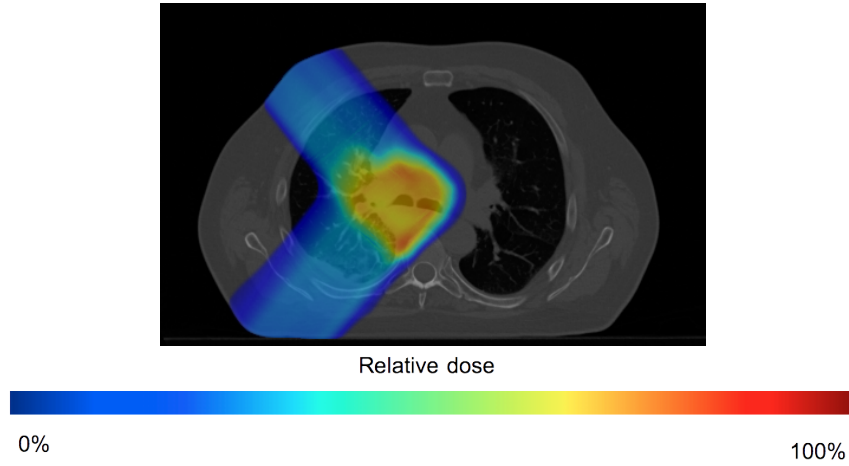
Exemple d’une image CT et de la représentation de la répartition de dose simulée dans MSPT.
